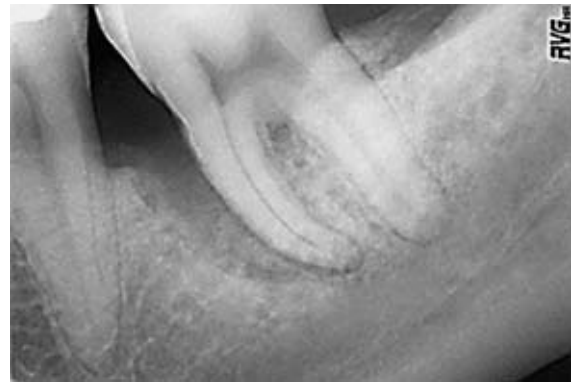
Radiograph of region 36.
